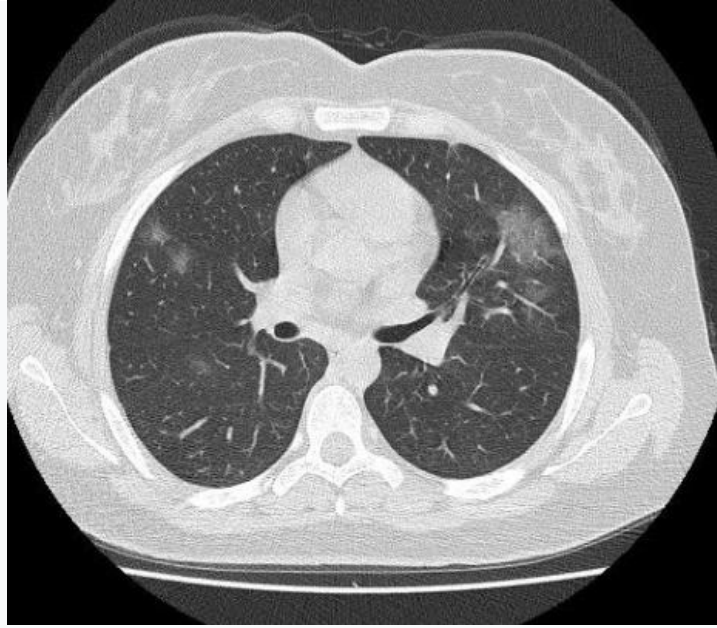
chest CT scanner of the first patient
